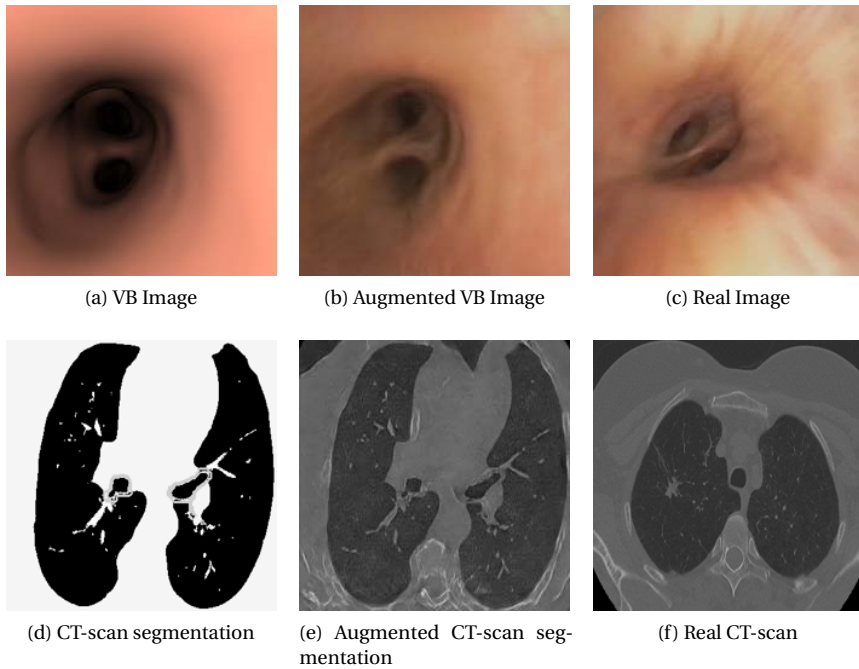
Virtual, augmented and real images for both VB and CT-scans domains.
